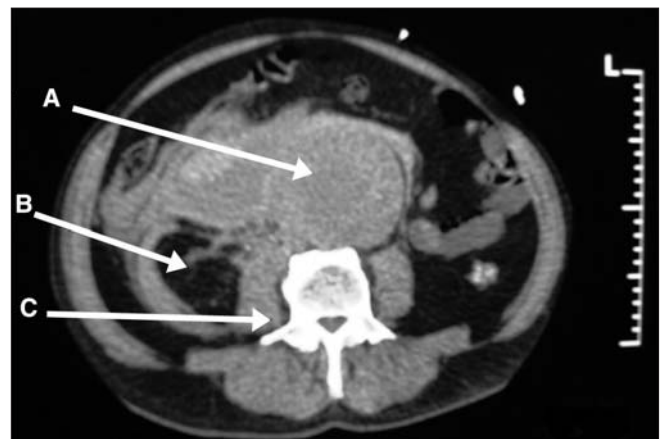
A CT scan showing a large 9-cm infrarenal aortic aneurysm extensively leaking around the right kidney and psoas muscle. A = ruptured abdominal aortic aneurysm; B = right kidney; C = right psoas muscle surrounded by blood.
